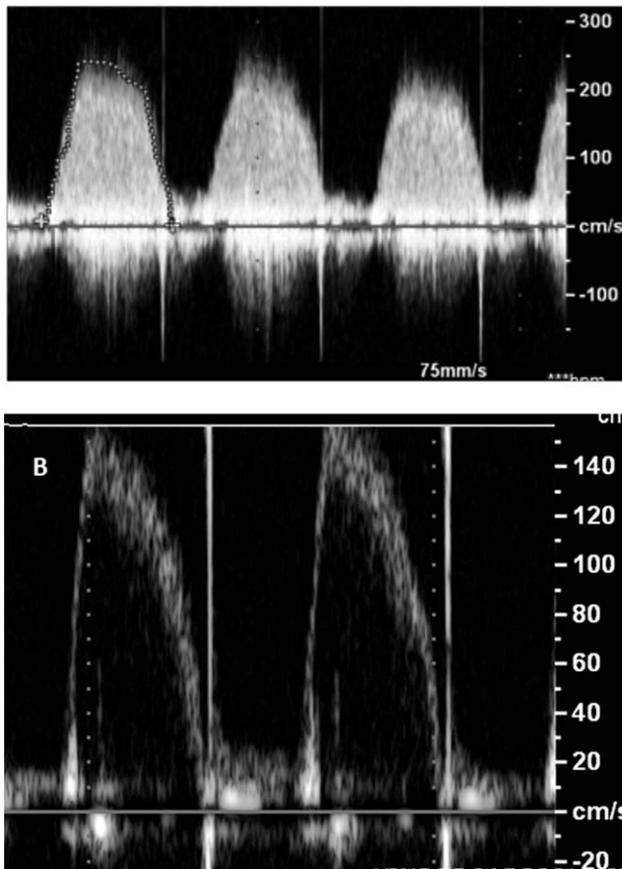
Tricuspid valve stenosis. (A) Continuous wave Doppler tracing shows high peak flow with a mean gradient of 13 mm Hg over the original valve-in-valve assembly pre-implantation of second valve-in-valve. (B) Pulsed wave Doppler tracing following second valve-in-valve implantation demonstrates markedly reduced peak flow.
